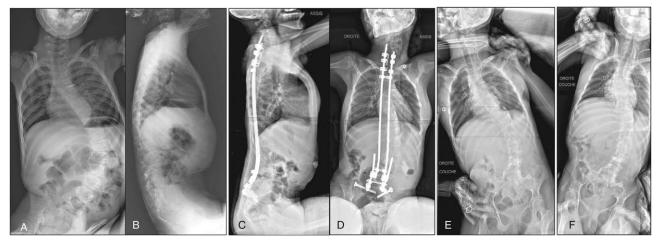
A 15-year-old girl with cerebral palsy. (A and B) Initial AP and lateral x-rays; (C and D) after initial surgery; (E and F) lateral bending after removal of instrumentation for chronic infection, 8 years after initial surgery.
